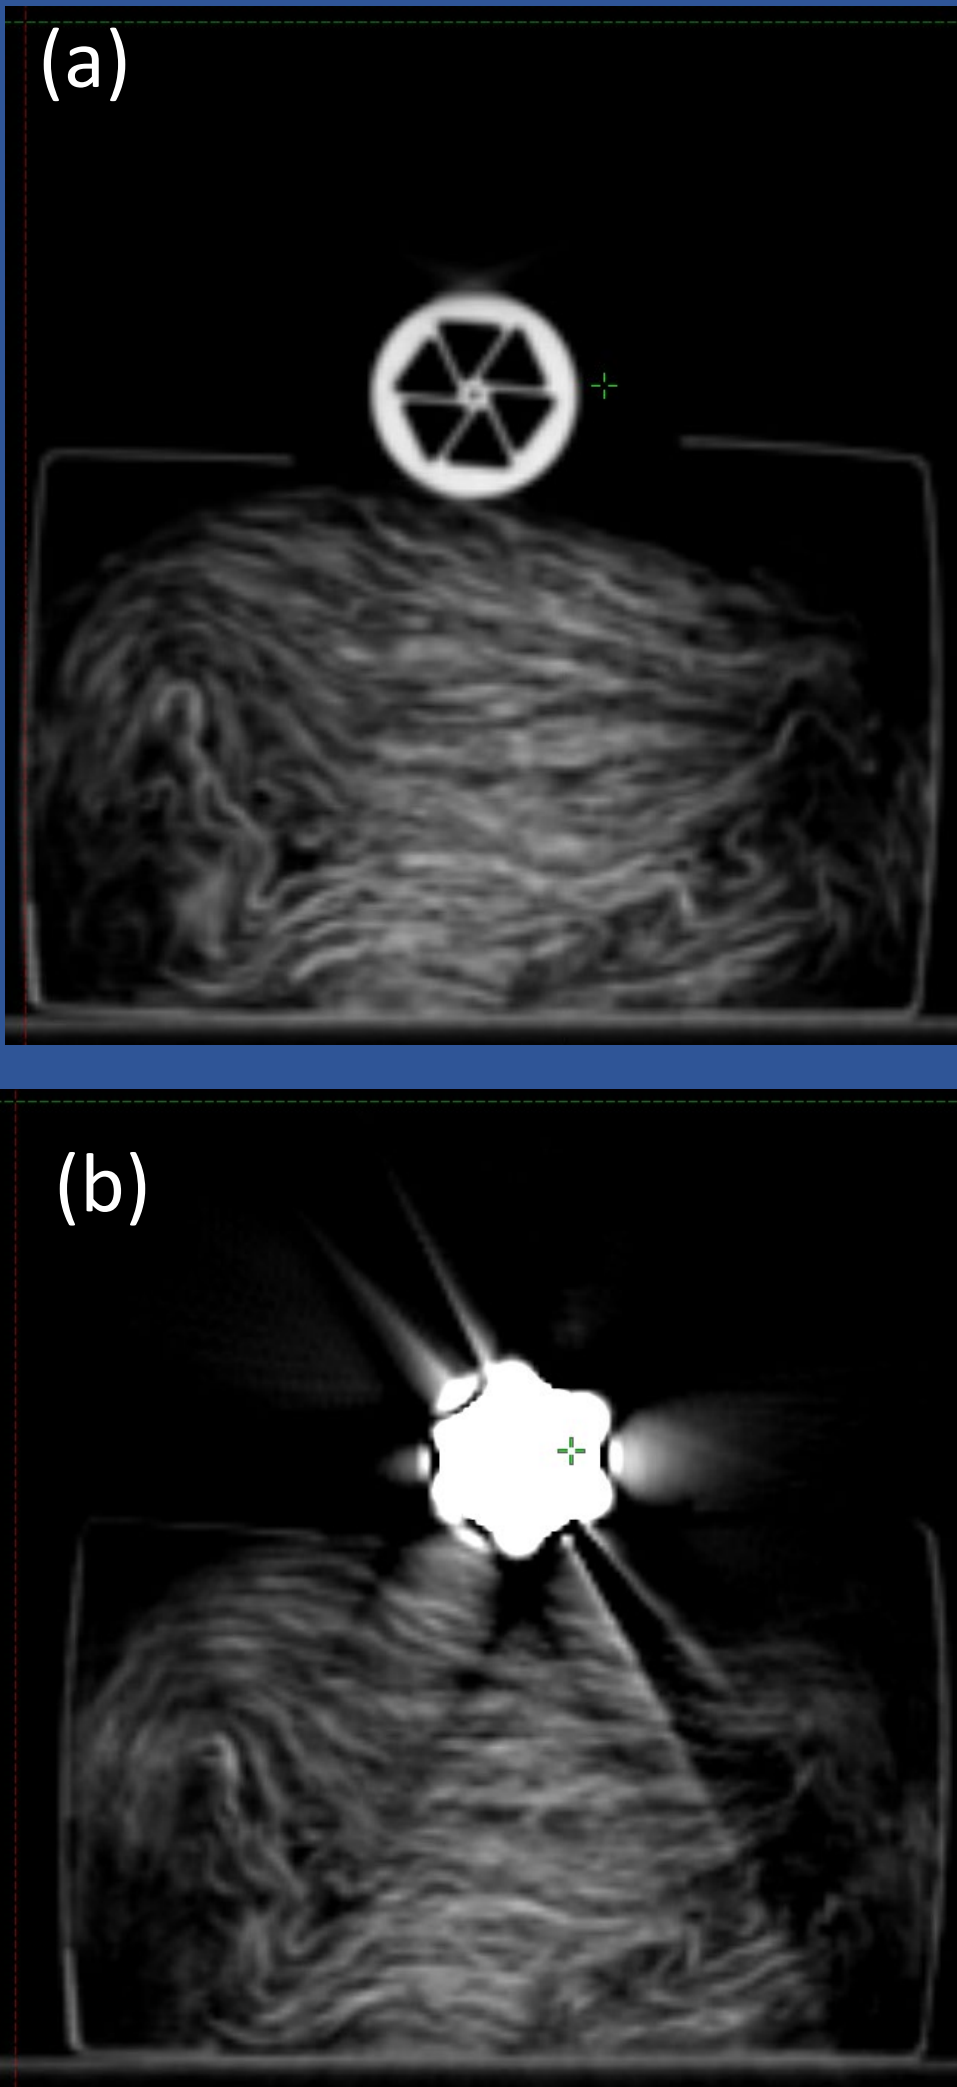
CBCT imaging of designed cylinder both without placement of modular shielding (a) and with tungsten shielding in plan (b). The modular design of the shielding allows for its removal during imaging occurring prior to treatment to assure proper placement.
